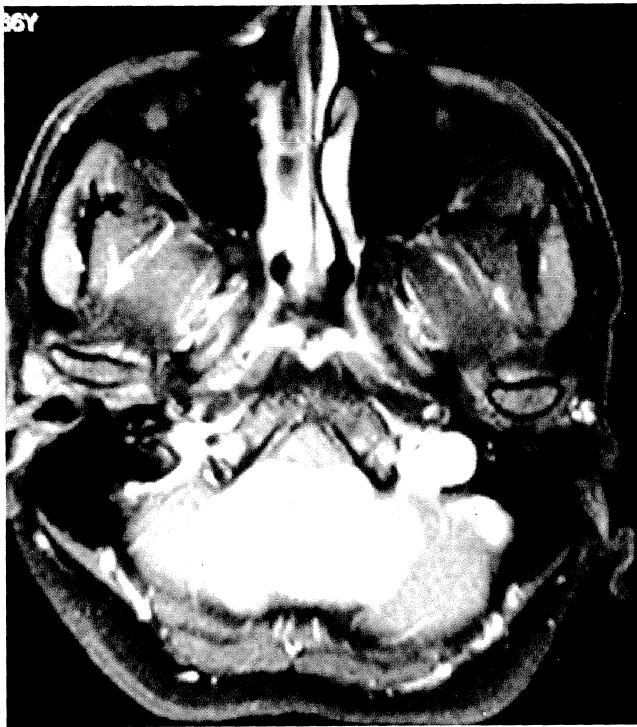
Post contrast MRI (Axial and Sagittal) of a patient with posterior foramen magnum meningioma
